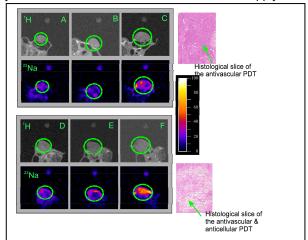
¹H & ²³Na MRI of tumors evolution (A-before, B-2 h, C-11 days after antivascular PDT, D-before, E-2 h, F-11 days after anticellular & antivascular PDT).
